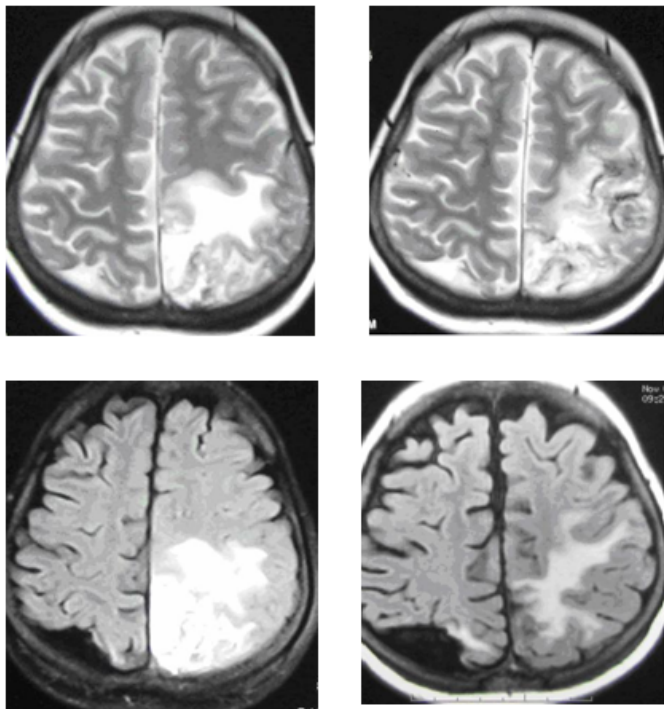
MRI findings according to disease course are shown.
